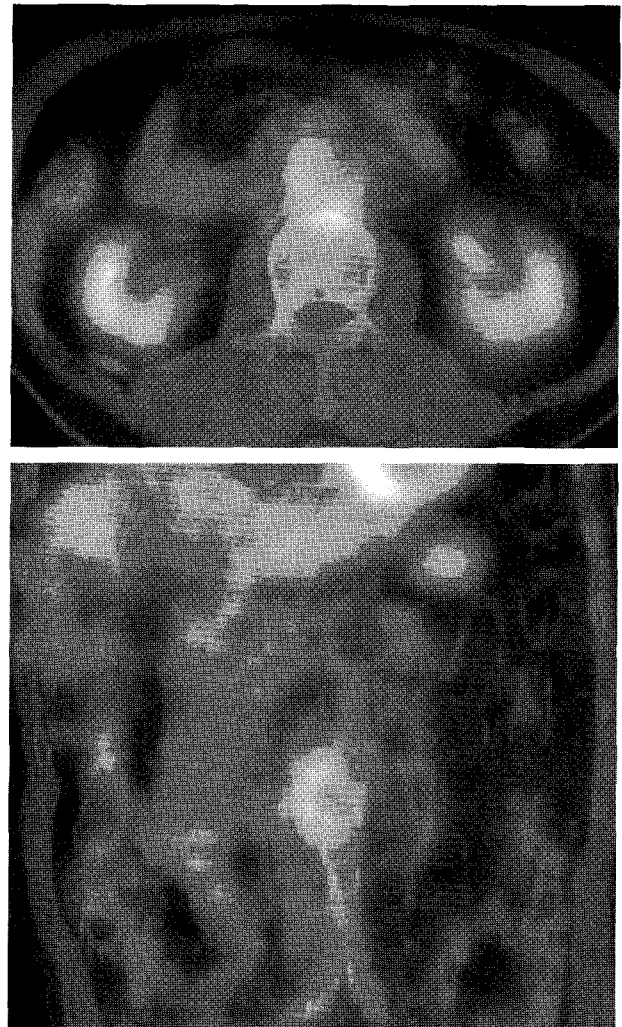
Repeat axial and coronal images of F-18 FDG PET/CT at the same level, one month after the first PET/CT, show decreased F-18 FDG uptake (maxSUV=3.61) in right wall of infrarenal abdominal aorta and periaortic space.
